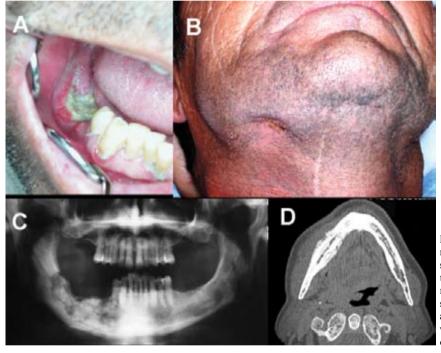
A-D. (A): Three months later appeared necrotic bone and mucosal inflammation and (B): soft tissue swelling and extraoral purulent fistula to the right sub-mandibular region. (C): The panoramic x-ray showed a great area of osteolysis with sequestrums and bone necrosis. (D): In the CT scan a sclerosis area was observed in the mandible along with irregularities in cortical bone and affectation of soft tissues.
